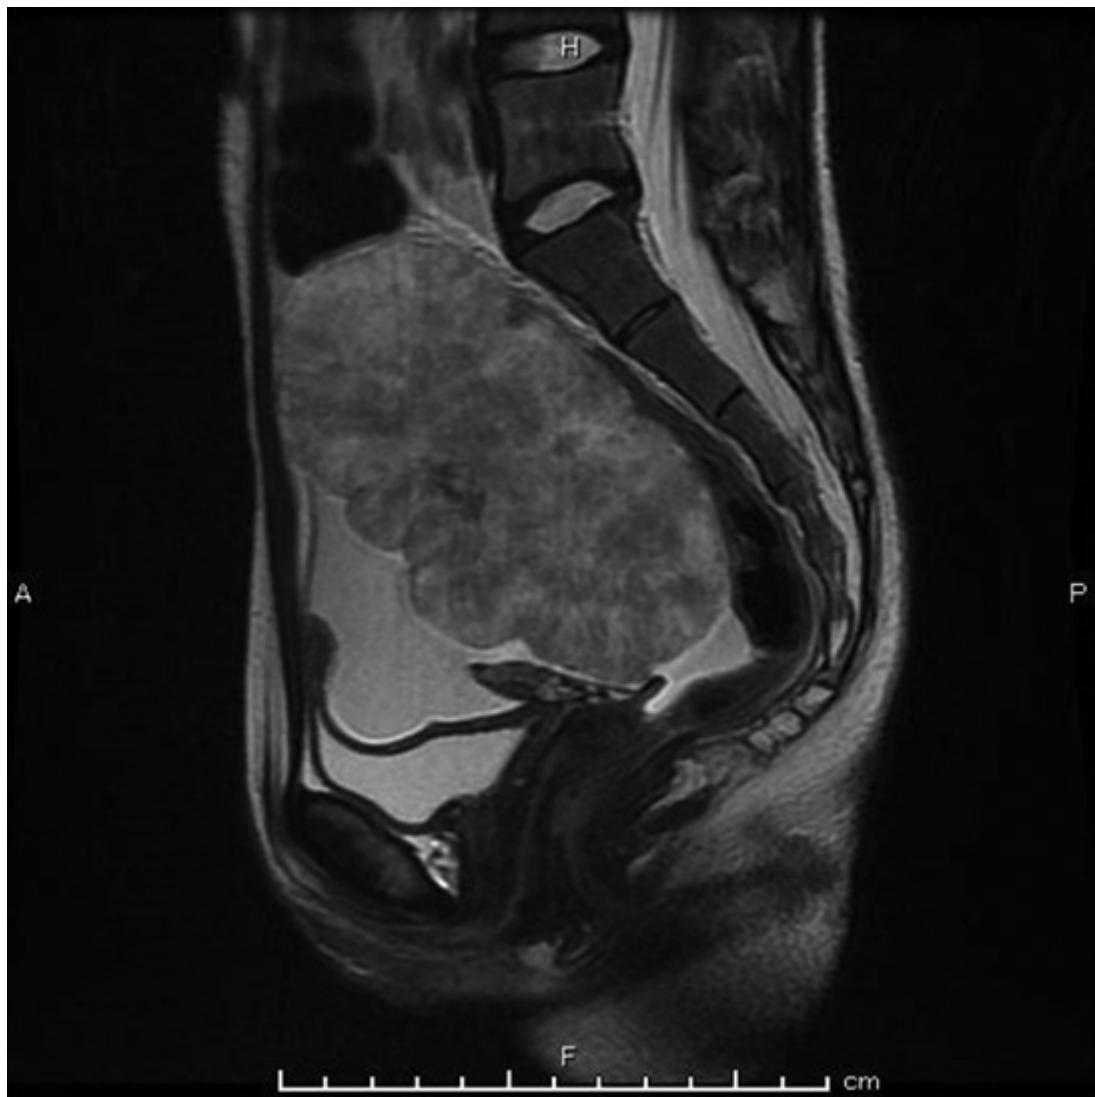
Contrast-enhanced MRI of the abdomen. A large neoplastic lesion, approximately 12 cm in size, with a heterogeneous contrast effect was observed in the right ovary (shown in Fig. 2). MRI, magnetic resonance imaging.
